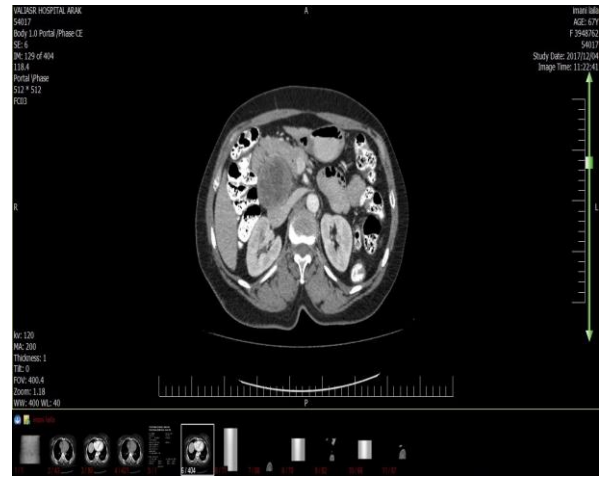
Preoperative CT scan of abdomen showing large cystic mass in head of pancreas.
